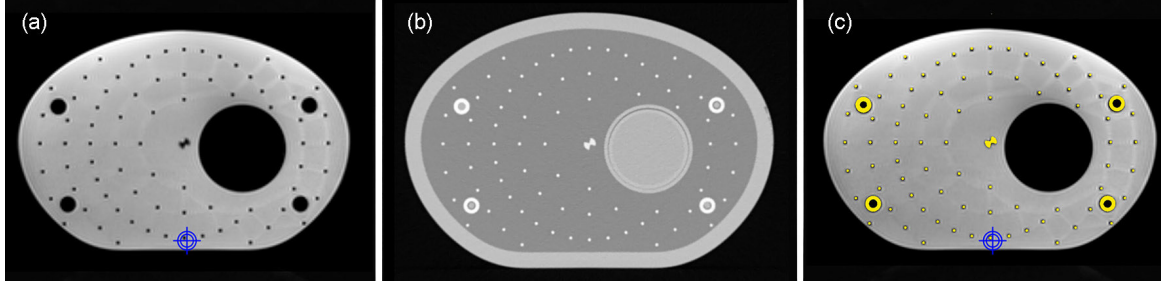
(a) Transverse MR image (3D T_1 GRE) and (b) CT image of the 3D distortion grid. (c) The threshold segmented grid structure (yellow) of the CT scan was rigidly registered with the MR scan based on the grid point closest to the magnetic isocenter (blue target).
